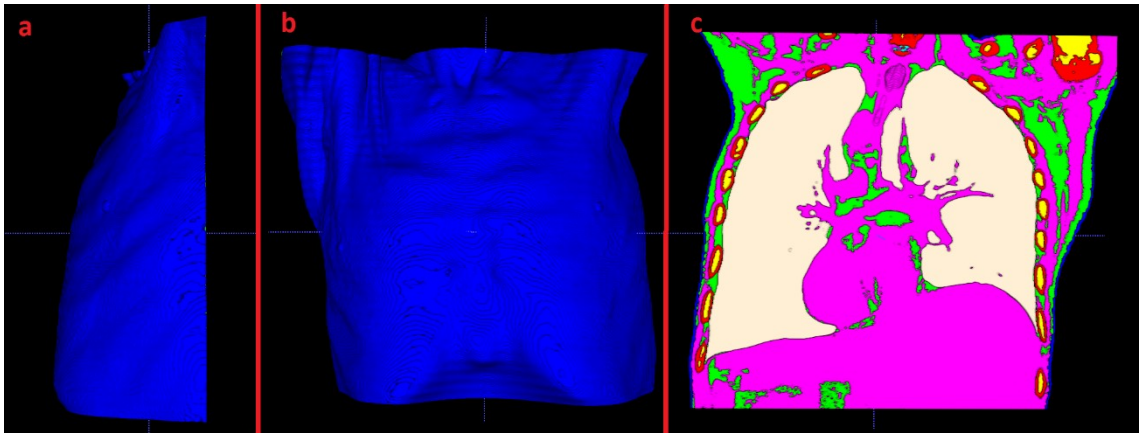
Region segmented from both CT images. Lateral view (a), anterior view (b) and posterior view (c) of the segmented region.
